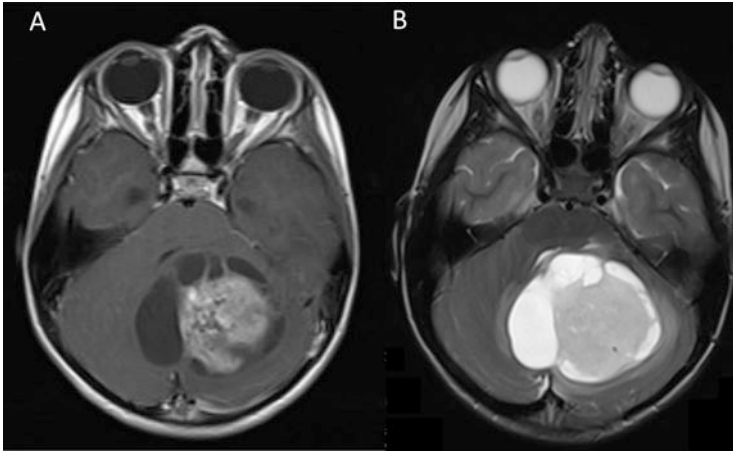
4-year-old with a large $5.4 \times 5.8 \times 5.2$ cm mass, a pilocytic astrocytoma located in the left cerebellum with extension across the vermis into the medial aspect of the right cerebellar hemisphere. (a) T1 post-gadolinium. (b) T2-weighted image
